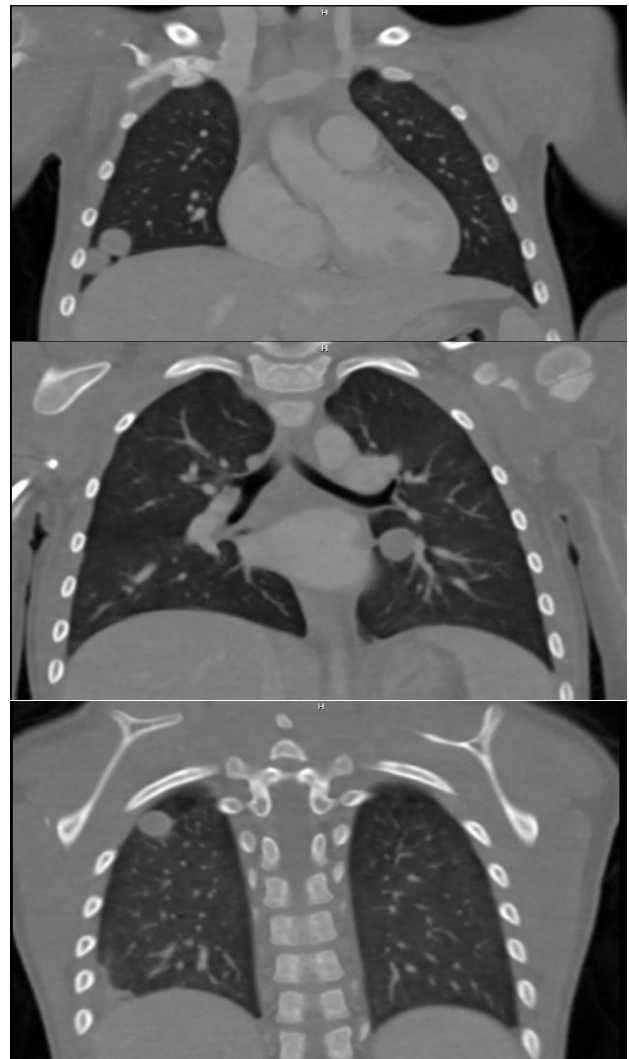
CT of chest showing multiple large lung nodules.
